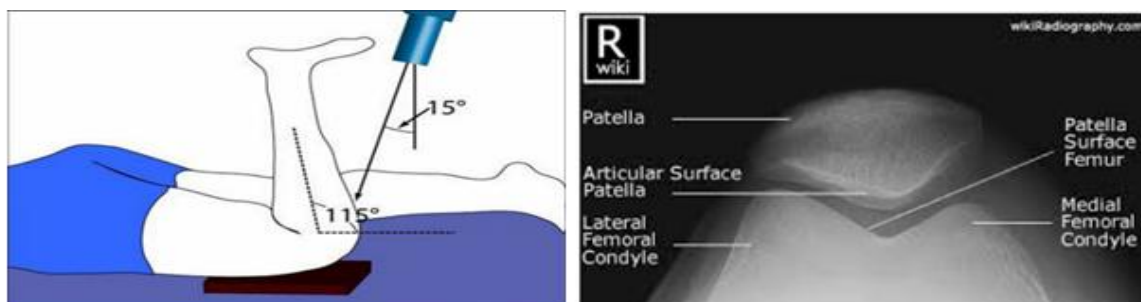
The standard skyline (sunrise or tangential) view demonstrates the knee positioned in flexion with appropriate support, allowing a caudally directed tangential X-ray beam to pass through the patellofemoral joint. The resulting axial radiograph clearly depicts the patella, patellofemoral joint space, and femoral trochlear surfaces for assessment of alignment and congruence.
